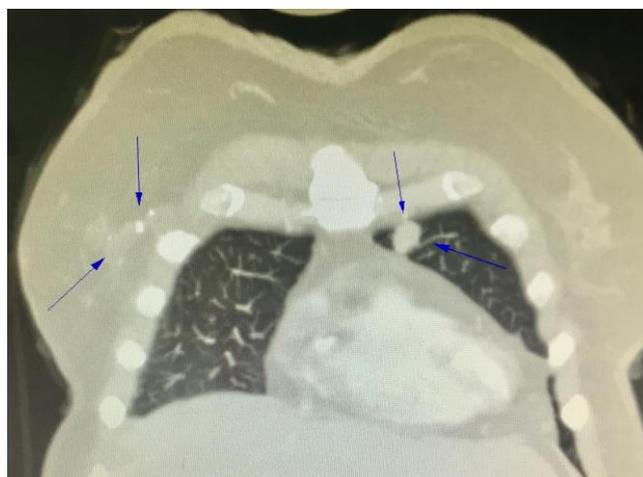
Thorax computed tomography showing a 13x15 mm solid nodule in left lung upper lobe (Coronal section)
